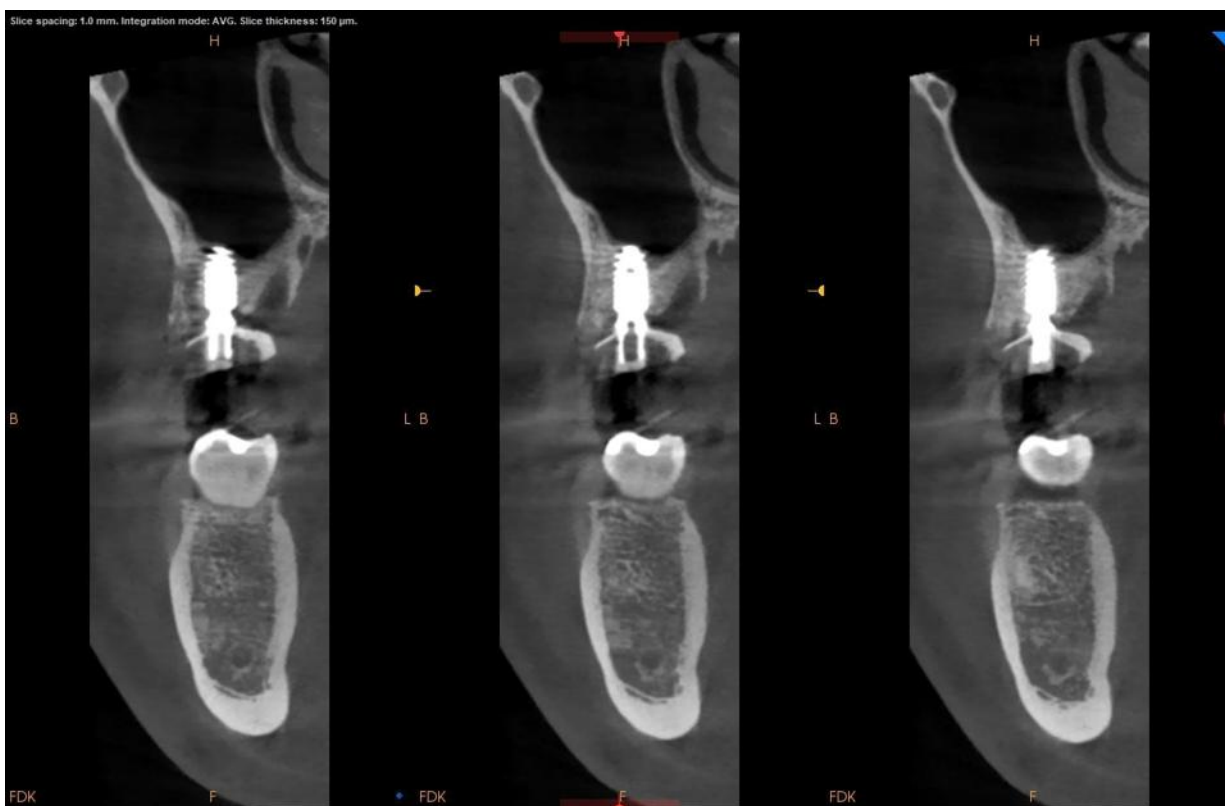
Postoperative cross-sectional CBCT views showing implant position relative to residual bone and the maxillary sinus.
